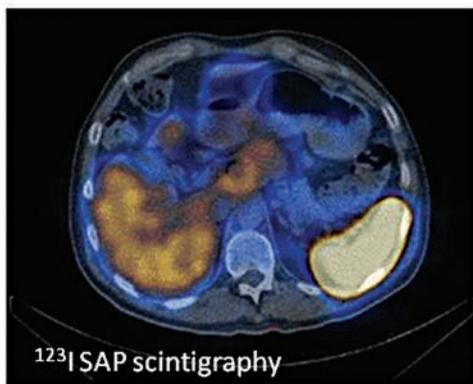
Radionuclide imaging in amyloidosis: ¹²³I labeled serum amyloid P component scintigraphy showing uptake in the spleen and liver in a patient with AL amyloidosis (left). The middle panel shows low-grade cardiac uptake of ^{99m}Tc-DPD in a patient with AL amyloidosis compared with marked cardiac uptake of ^{99m}Tc-DPD in a patient with wild-type transthyretin (senile cardiac) amyloidosis (right panel).
